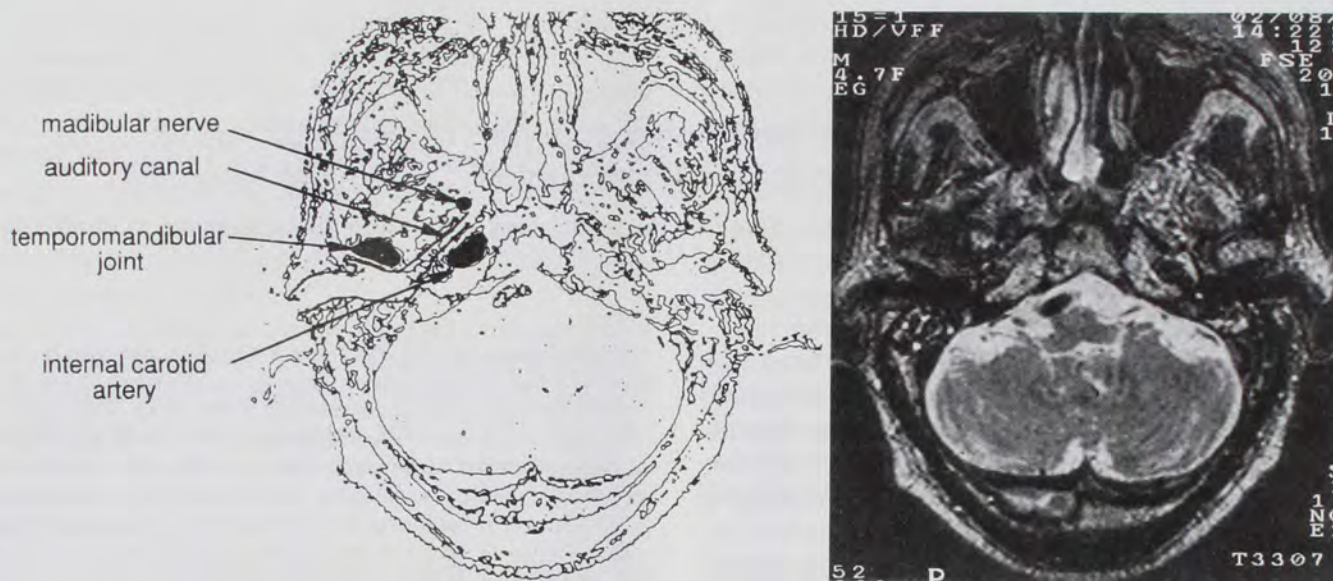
Left, A figure directly constructed from the magnetic resonance image. Right, Magnetic resonance image shows the anatomic relationship between the mandibular nerve and the auditory canal.
